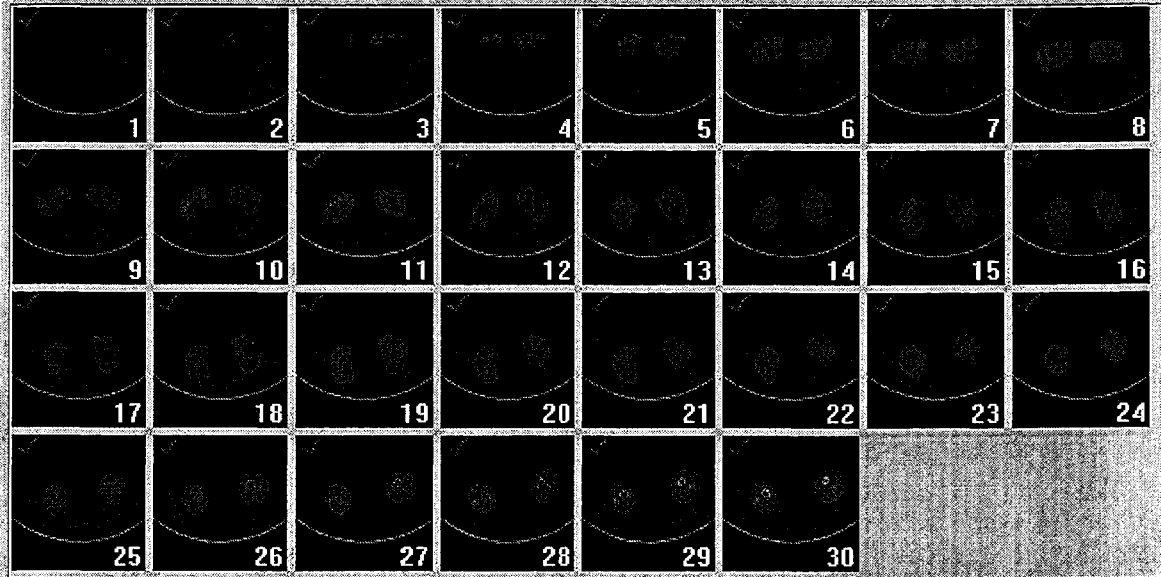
MRI scan data of clubfoot of Patient III
